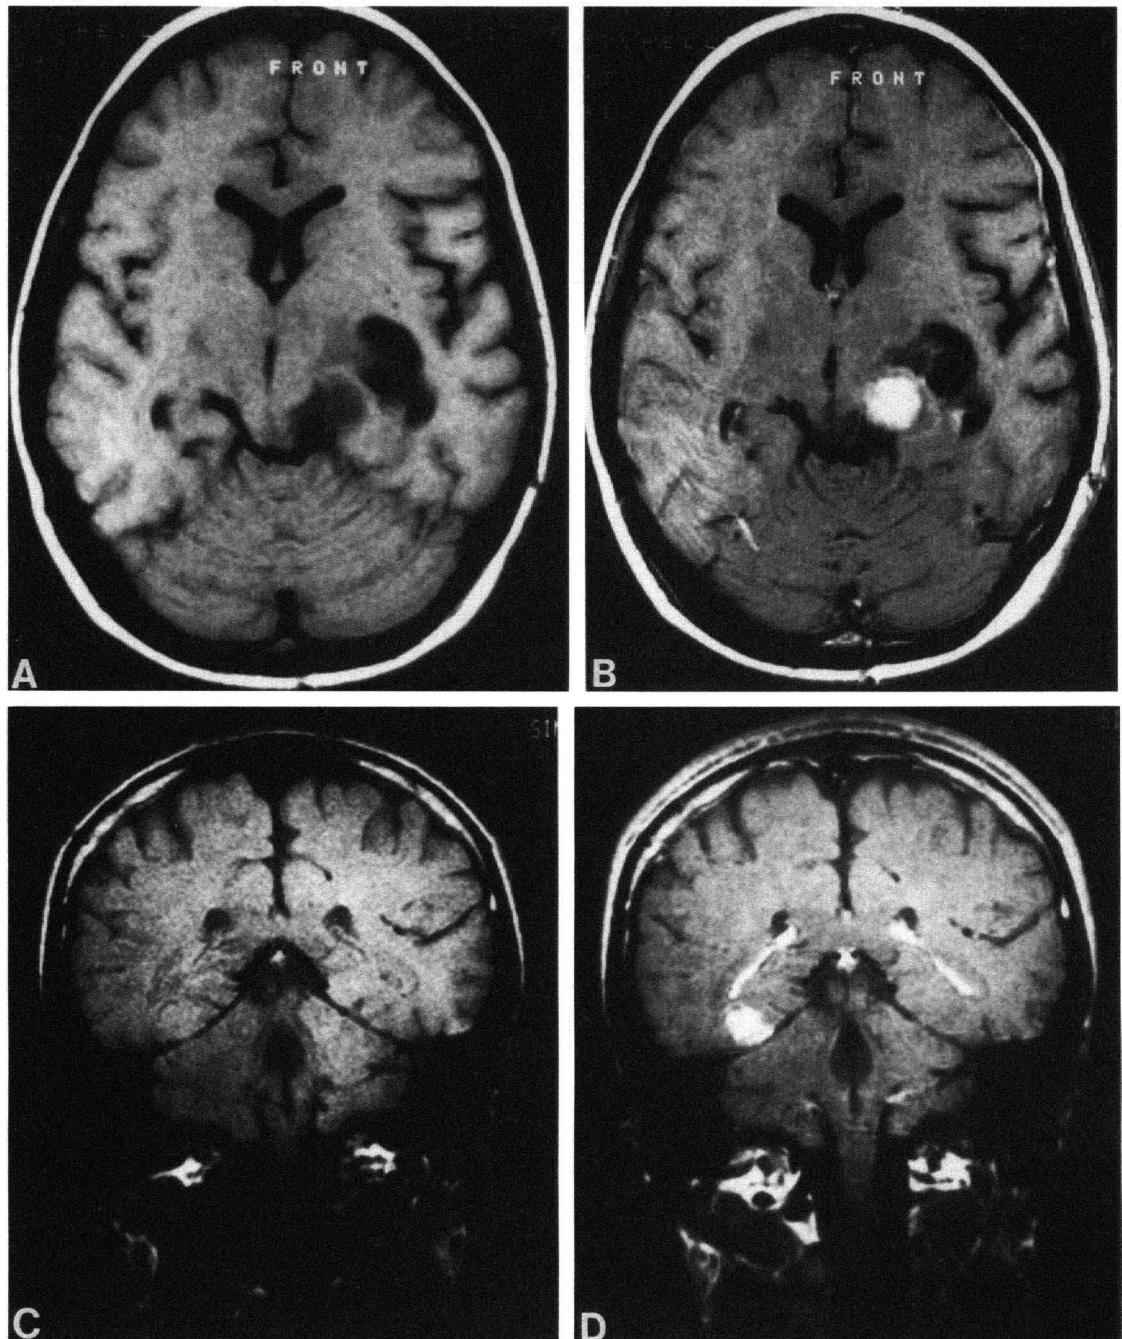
MRI scans of pilocytic astrocytoma. A: Case 1: noncontrast T1-weighted image demonstrating a hypodense area in the left thalamic region. B: Case 1: gadolinium-enhanced T1-weighted image demonstrating strong enhancement of the tumor. C: Case 2: noncontrast T1-weighted image demonstrating the isodensity of this posterior temporal tumor. D: Case 2: gadolinium-enhanced T1-weighted image demonstrating strong enhancement of the tumor.
